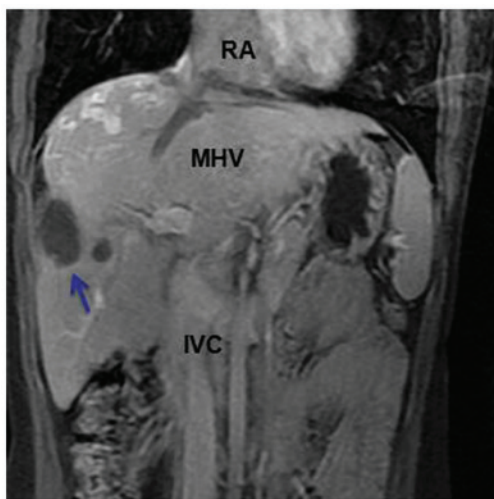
Magnetic resonance imaging demonstrating shrinkage of the right atrium tumor thrombus prior to its eventual disappearance. The liver tumors (arrow) and the tumor thrombus in the inferior vena cava and middle hepatic vein are also markedly reduced in size. RA, right atrium; MHV, middle hepatic vein; IVC, inferior vena cava.
